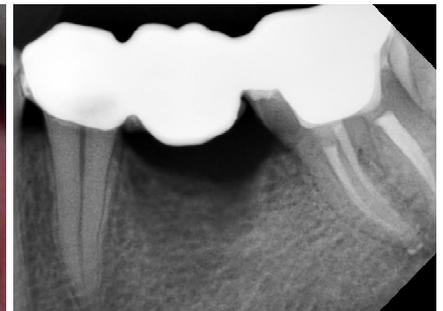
Post cementation radiograph
